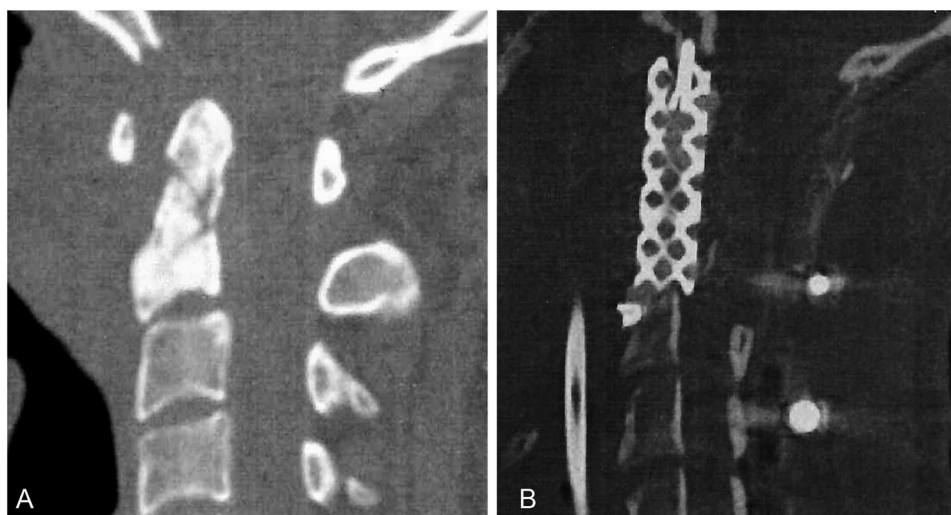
Preoperative sagittal computed tomography (CT) scan image demonstrating C1 and C2 infiltrating bony erosion with C1-C2 instability (A). Postoperative sagittal CT scan image showing replacement of the anterior column of high cervical spine by a titanium mesh cage filled with cement bone and fixed to the clivus (B).
